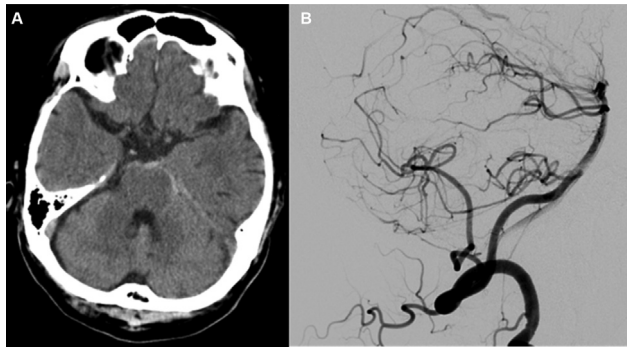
(A) A computed tomographic scan, taken 3 years ago, showing the subarachnoid hemorrhage confined to the periphery of the brainstem. (B) Distal subtraction angiogram, performed 3 years ago, showing smooth vessel wall due to an unknown cause.
